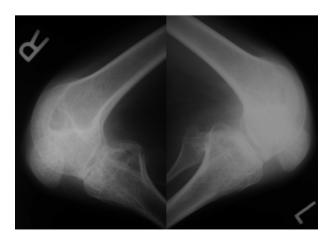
Preoperative lateral radiographs of the right and left knees showing "squaring" of the distal femoral condyles, preventing extension.
